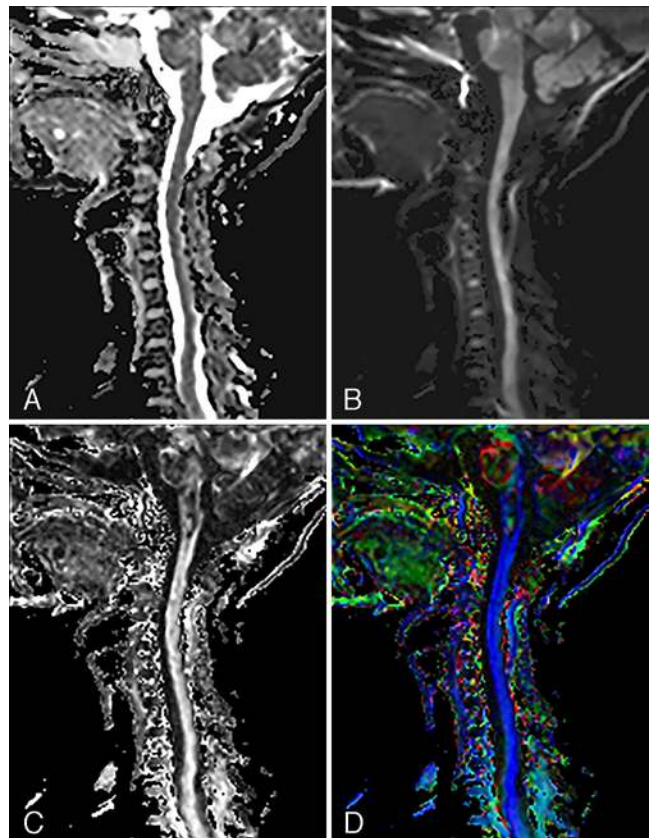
Representative sagittal ADC (A), diffusion-weighted (B), FA (C), and reformatted color FA (D) MR images acquired at 3 T of the cervical spine in Fig. 1 with uniform cord signal throughout each of the sequences, which is consistent with absence of an SCI. The FA sequence is a gray-scale map of DTI FA values, with brightness corresponding to more anisotropy. The reformatted color FA sequence assigns colors that are based on anisotropy and direction from the FA data.
